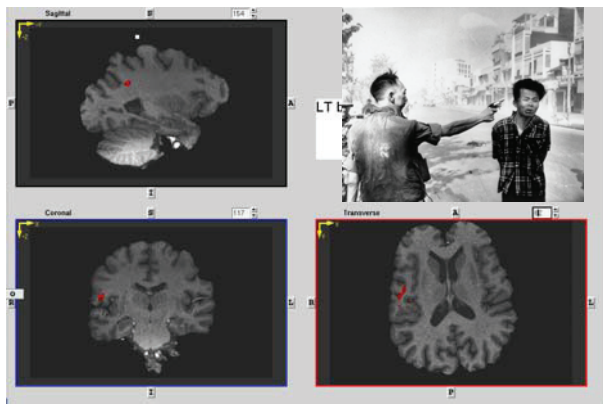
Functional MRI at baseline. A representative section of the baseline brain MRI of one (AA) of the test subjects who did not develop any CNS symptoms after six weeks of interferon therapy. Visual stimulus #2 (Figure 2) was used to generate this scan. There are only a few areas of activation (red). This pattern of lack of activation was seen in all test subjects who did not develop clinical depression while on treatment with INF.
